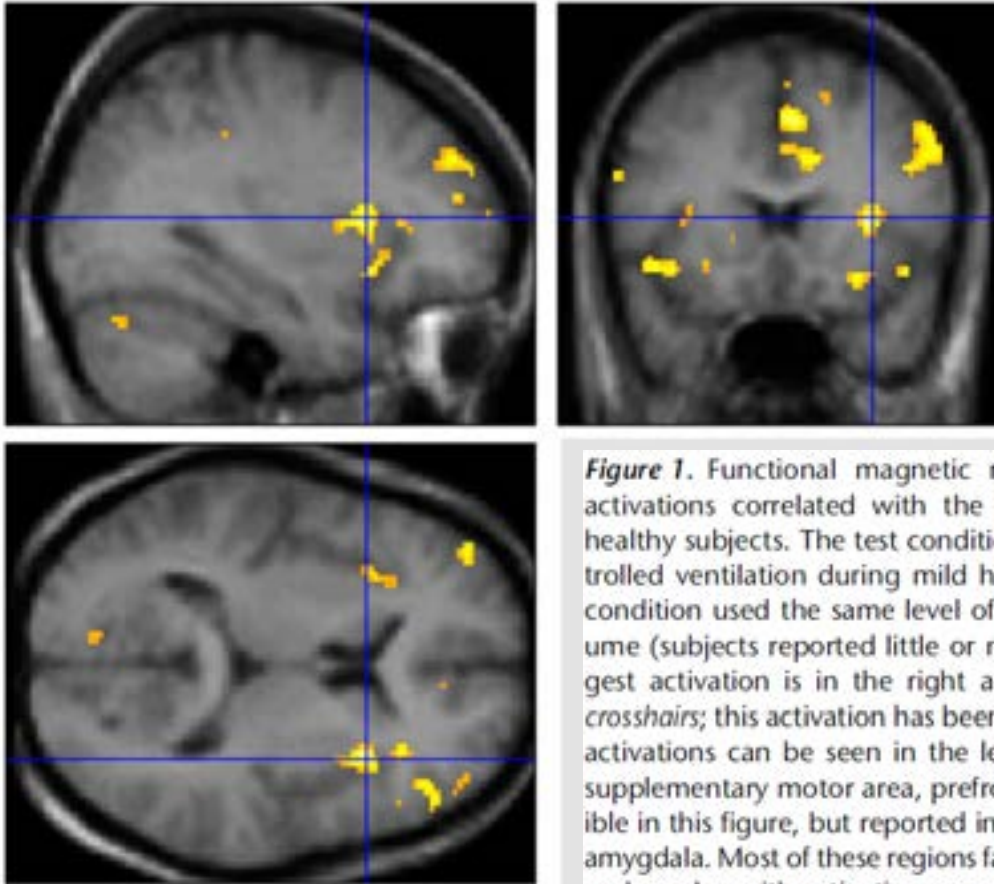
Functional magnetic resonance images showing cerebral activations correlated with the experience of strong air hunger in healthy subjects. The test condition consisted of low tidal volume controlled ventilation during mild hypercapnia; the baseline comparison condition used the same level of hypercapnia but with high tidal volume (subjects reported little or no discomfort at baseline). The strongest activation is in the right anterior insula, indicated by the *blue crosshairs*; this activation has been shown in a number of studies. Other activations can be seen in the left anterior insula, anterior cingulate, supplementary motor area, prefrontal cortex, and cerebellum. Not visible in this figure, but reported in the same study was activation of the amygdala. Most of these regions fall in the category of limbic/paralimbic, and overlap with activations seen during pain, thirst, fear, and hunger. Reproduced and adapted with permission from Reference 137.
